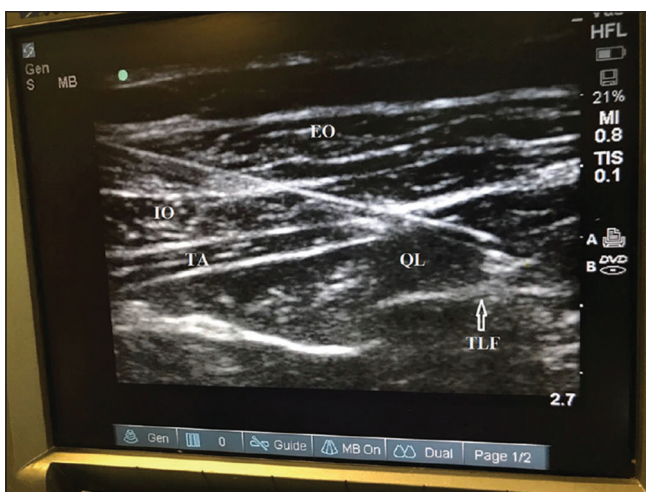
Ultrasound guided quadratus lumborum block. EO: External oblique muscle, IO: Internal oblique muscle, TA: Transverse abdominis muscle, QL: Quadratus lumborum muscle, TLF: Thoracolumbar fascia
